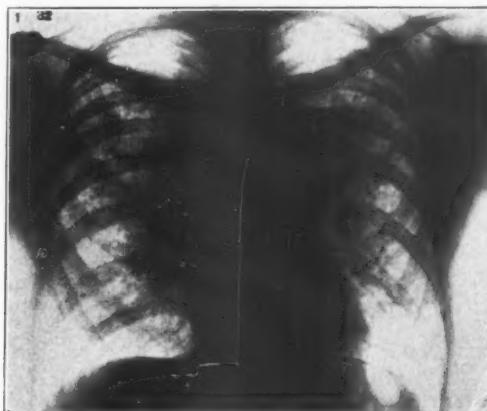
(Case 3). A roentgenogram of the chest obtained four days after the onset of a paroxysmal seizure of pulmonary hemorrhage. Note that both the bases and apices are now clear, while the root shadows are still markedly accentuated.
